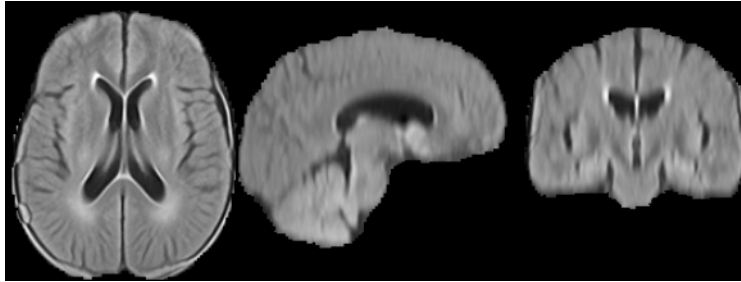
The initial T2-FLAIR atlas constructed from low resolution stroke patient images. Note the white matter hyperintensity and interpolation artifacts visible near and in the ventricles.
